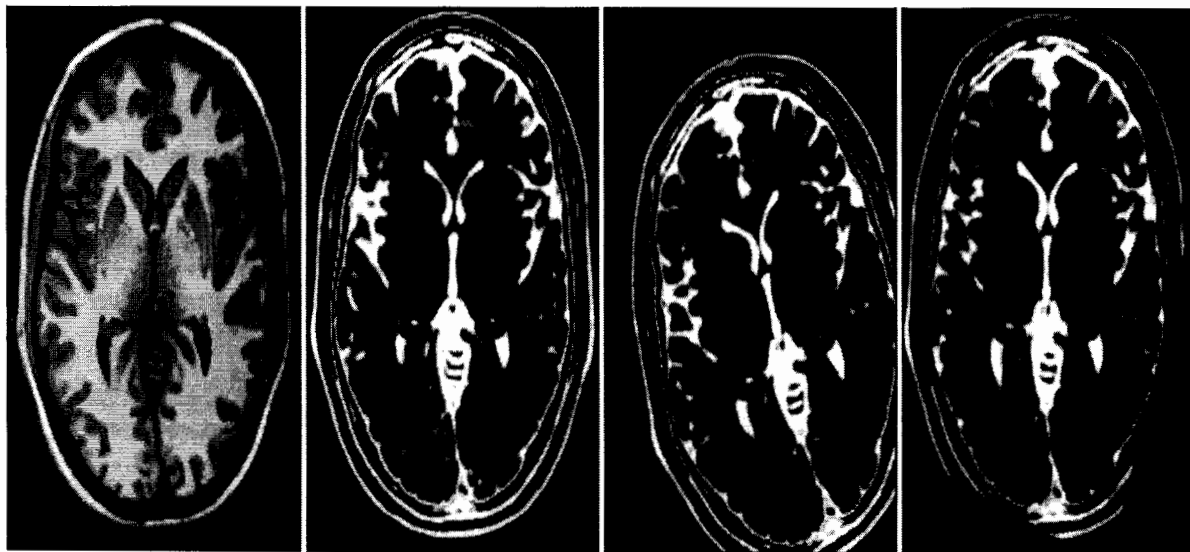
Magnetic resonance images co-registration.
